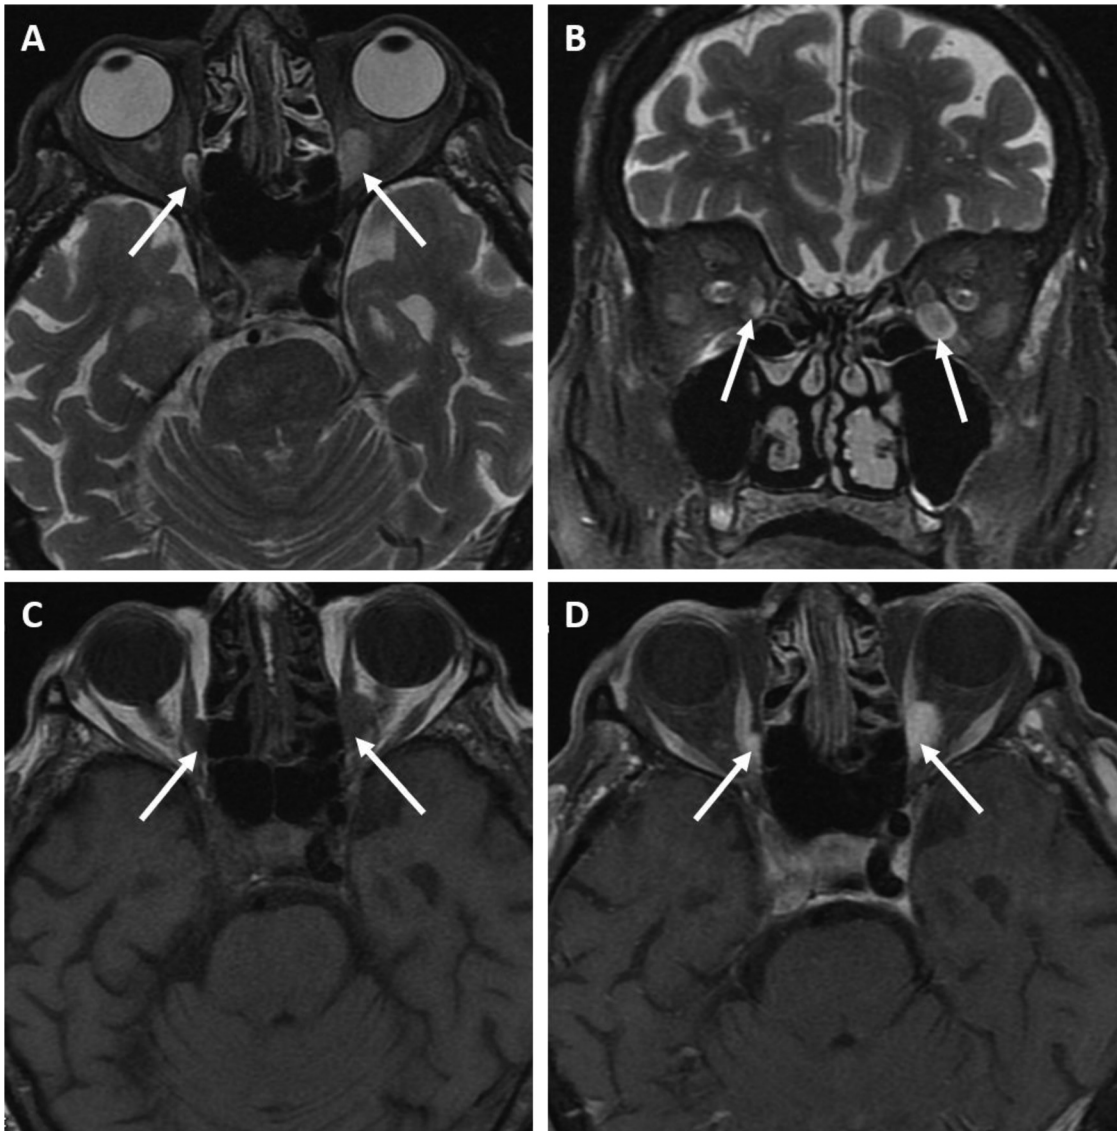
MRI examination, axial (A) and coronal T2-weighted FATSAT (B) images, axial T1-weighted unenhanced (C), and enhanced (D) images. MR revealed bilaterally in medial part of the orbits oval lesions (arrows) presenting low signal on T1 and high signal on T2 images. After contrast administration, masses showed intense homogenous enhancement. Additionally, on T2 images (A, B), there was a low signal “flow void” visible inside the oval lesions confirming the nature of the orbital masses to be vessels—these MRI findings were initially not noticed; therefore, the lesions were misinterpreted as orbital tumors.
